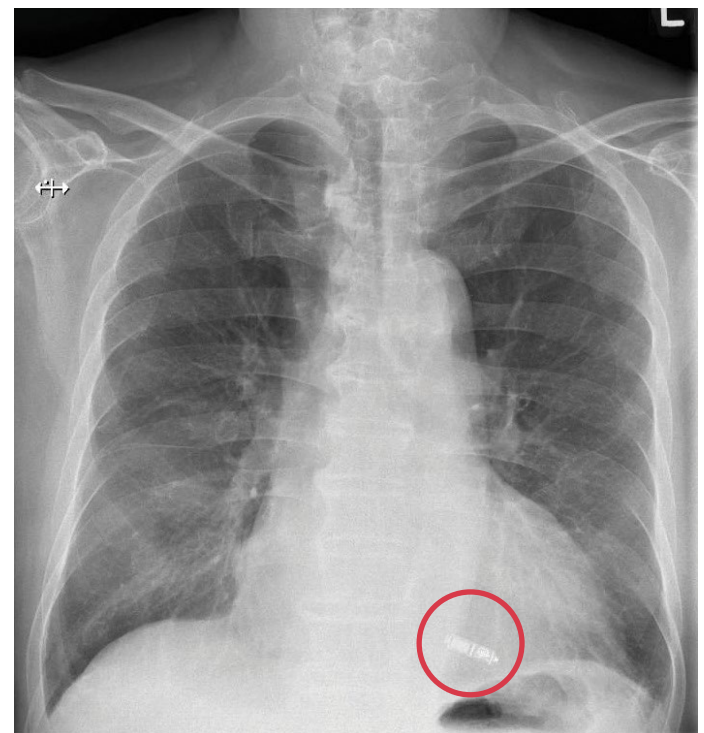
Leadless pacemaker on Chest X-ray (CXR), near the cardiac apex
